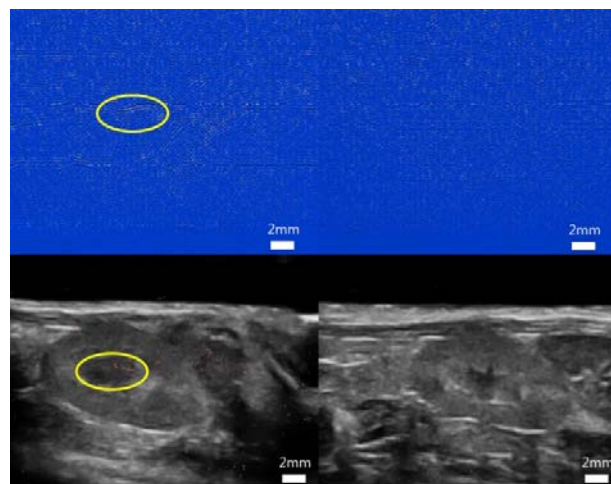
Overlaid image with PAT and ultrasound obtained by injecting Contrast agent & Histamine into Kidney
